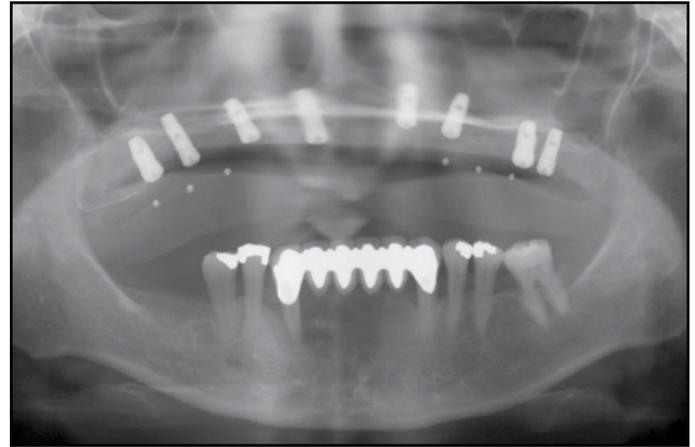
Panoramic radiograph following dental implant delivery.
